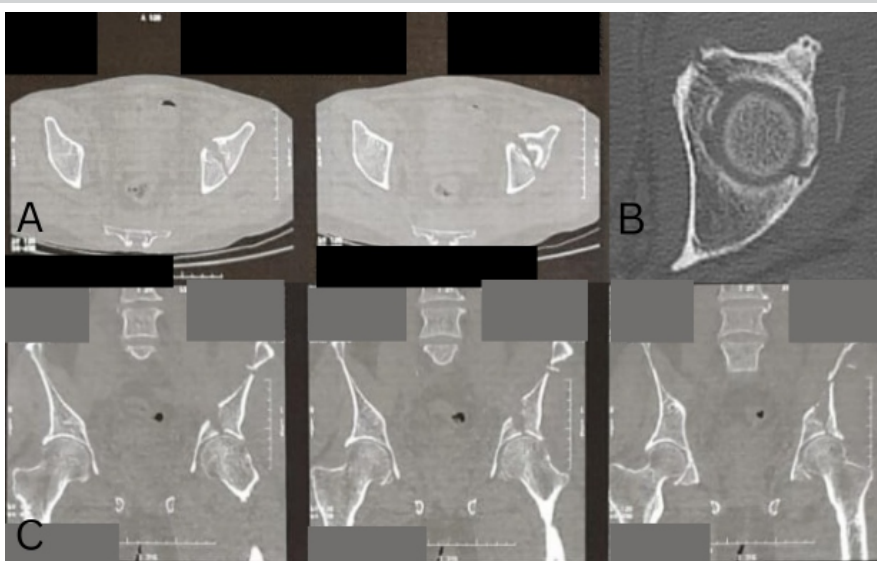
Pre-operative computed tomography scan (A) Sagittal view (B) Axial view (C) Coronal view.
